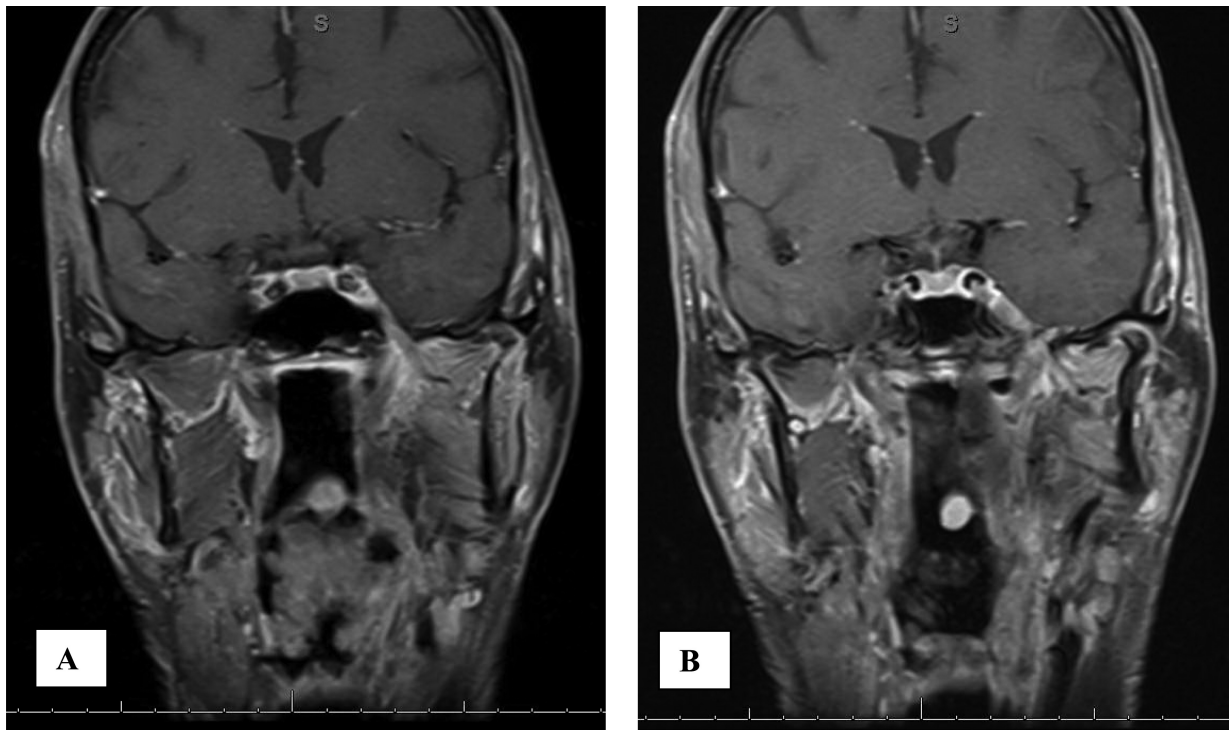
Coronal T1 MRI postcontrast and fat saturated demonstrating enhancing tumor proven to be squamous cell carcinoma (A) in the left infratemporal fossa tracking up V3 through foramen ovale and (B) extending intracranially into Meckel cave.
